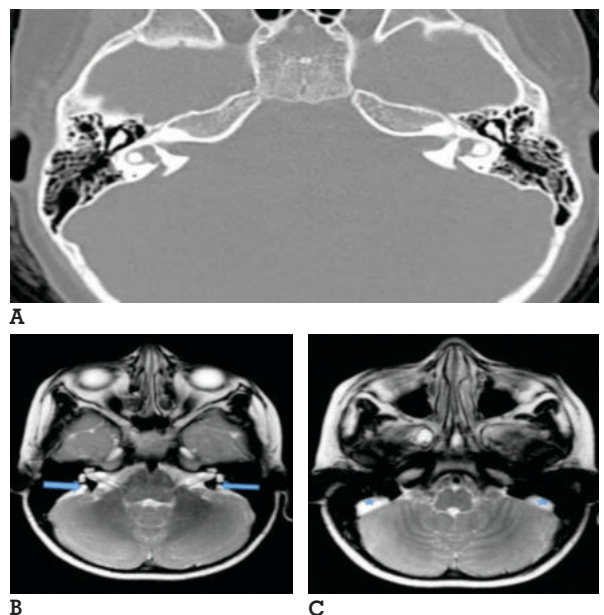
B/L Enlarged Vestibular Aqueduct and Endolymphatic duct and sac. A) Axial HRCT image shows bilateral enlarged vestibular aqueduct. B) T2 weighted MR image at the level of vestibular Aqueduct demonstrate bilaterally dilated Endolymphatic duct (arrow) C) MRI section slightly below the above section shows B/L enlarged endolymphatic sac (star mark).
